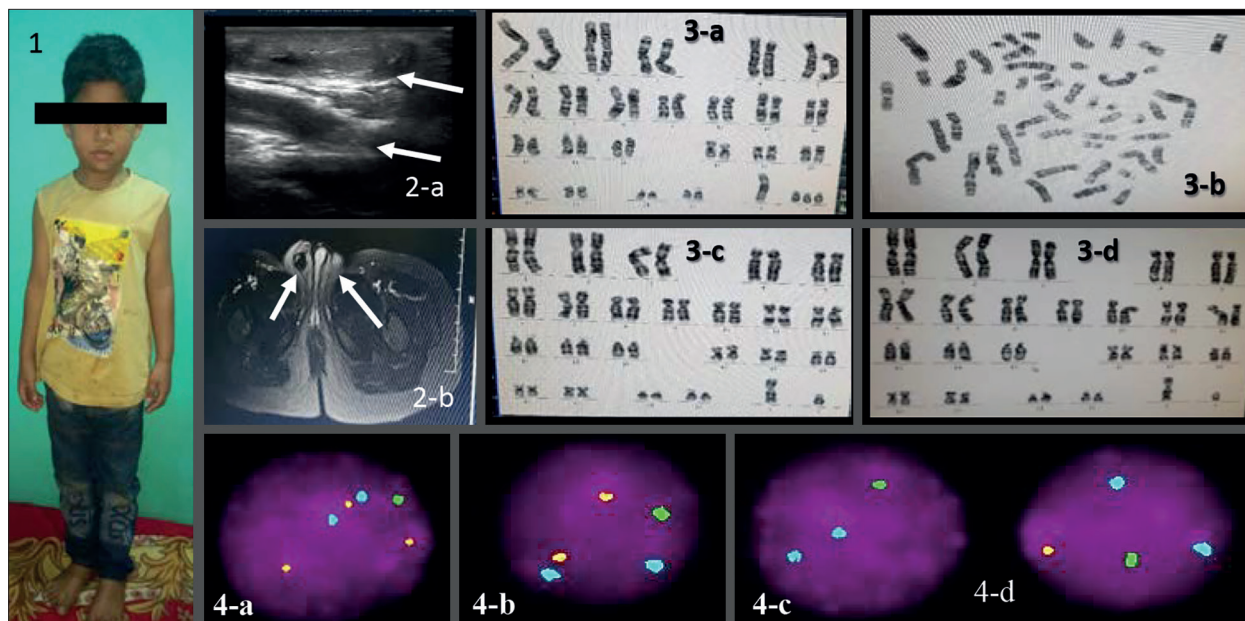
(1)- phenotype of proband. (2-a) ultrasonography (2-b) MRI shows absence of right testis and presence of right testis (arrow). (3-a) shows karyotype of proband, (3-b) shows metaphase spread of proband, (3-c, 3-d) shows karyotype of father and brother of proband. (4-a-d) shows FISH analysis. Green, orange, aqua signal shows X, Y & 18 chromosome respectively. (4-a)-XYYY pattern (73% cells), (4-b)-XYY pattern (7% cells), (4-c)- 1 X chromosome in each cell (13%), (4-d)- XY pattern in 7%.
